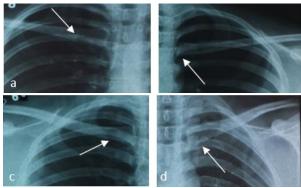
(a) Stage 2:17 years old male, right clavicle from PA chest radiograph, showing the nonossified epiphyseal cartilage. (b) Stage 3: 19 years old female, presenting left clavicle, PA chest radiograph, indicating the partially ossified epiphyseal cartilage. (c) Stage 4: 23 years male, right clavicle PA chest radiograph, showing complete ossification with discernible scar. (d) 25 years male, depiction of clavicle from chest radiograph, indicating that epiphyseal scar has vanished.
